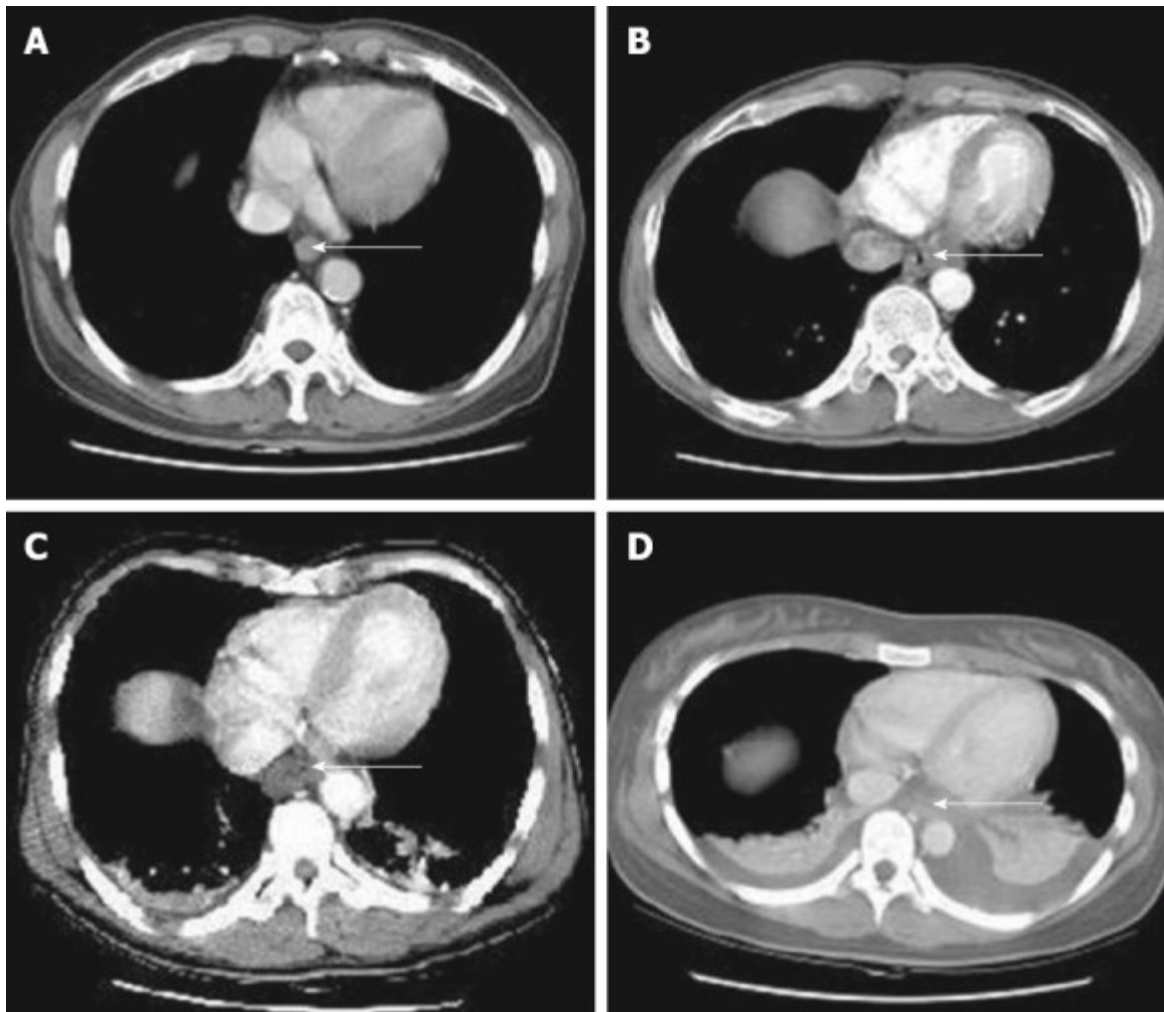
Computed tomography grading of esophageal caustic injuries. A: Grade 1; B: Grade 2; C: Grade 3; D: Grade 4. Reproduced from Ryu et al. Arrows show the esophageal wall.
